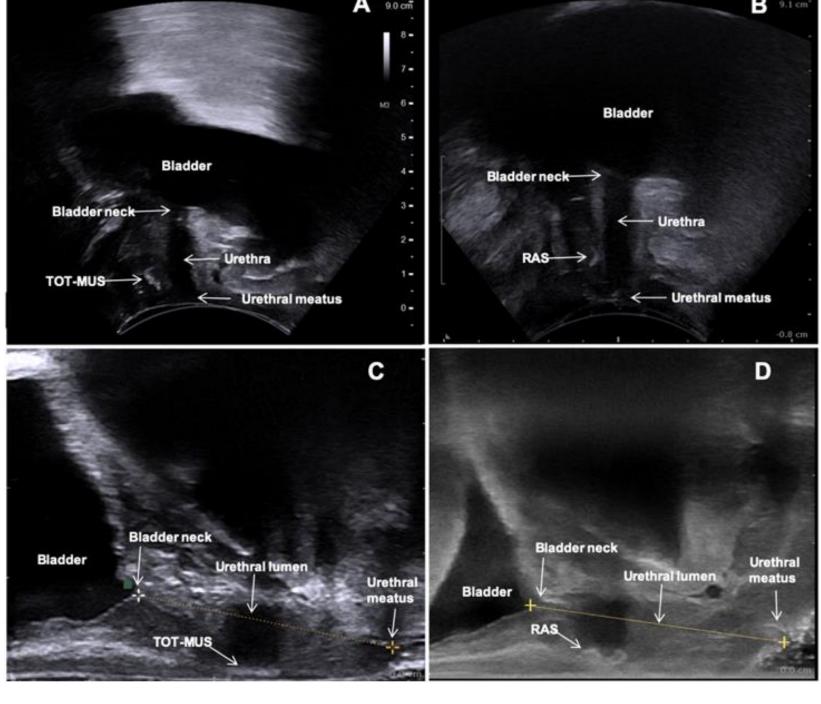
Static sonographic parameters of MUS (A) and RAS (B) evaluated by 2D-TPUS (probe 8802, FleshFocus 400, BK Medical) in the mid-sagittal plane; and by highfrequency EVUS (probe 8838) of MUS (C) and RAS (D).
